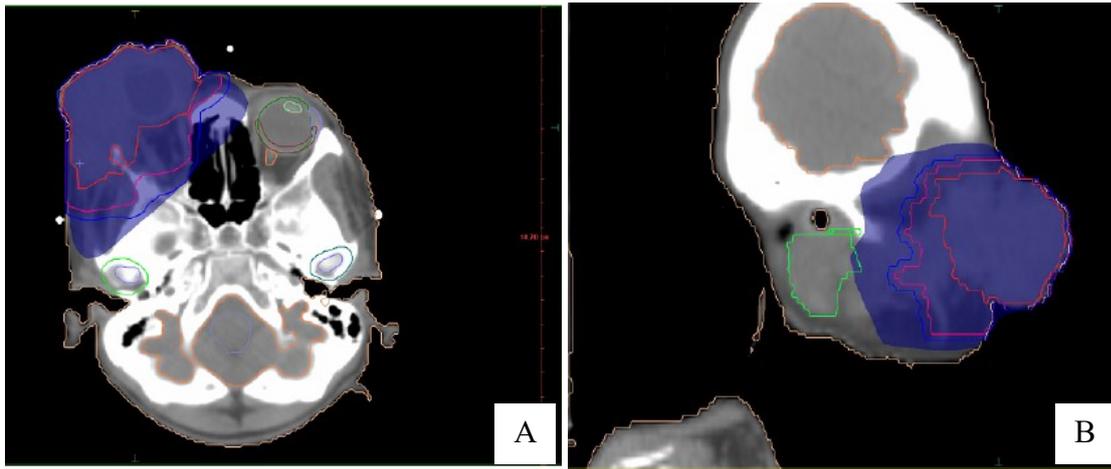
Dose color wash from a transversal (A) and a sagittal (B) planning CT scan
